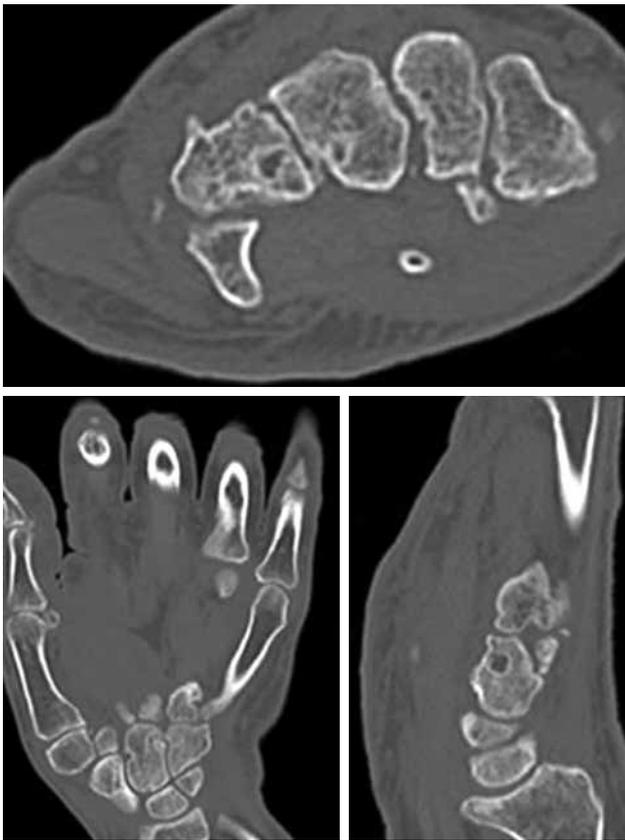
Final follow-up axial (a), coronal (b), and sagittal (c) computed tomography images that demonstrated grade II osteoarthritis according to Kellgren-Lawrence classification system.
